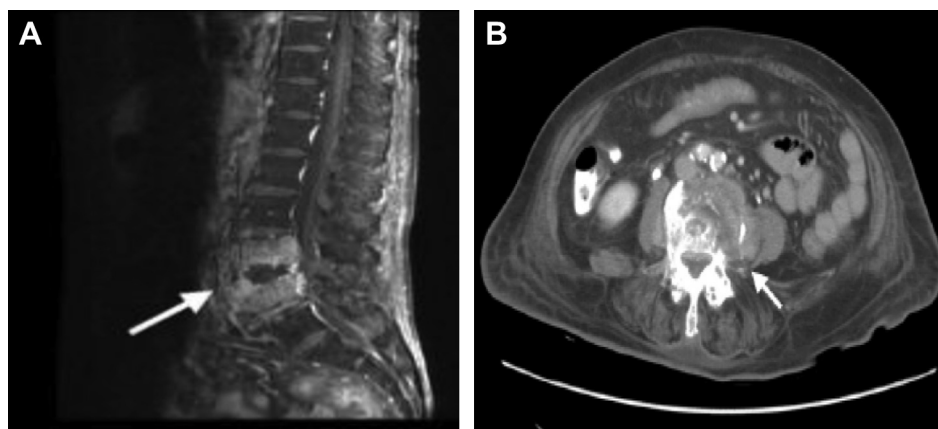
Spinal T2-weighted magnetic resonance images revealed (A) osteomyelitis and discitis at L4 and L5 with gadolinium enhancement (arrow), and (B) epidural abscess and psoas muscle abscess (arrow).
